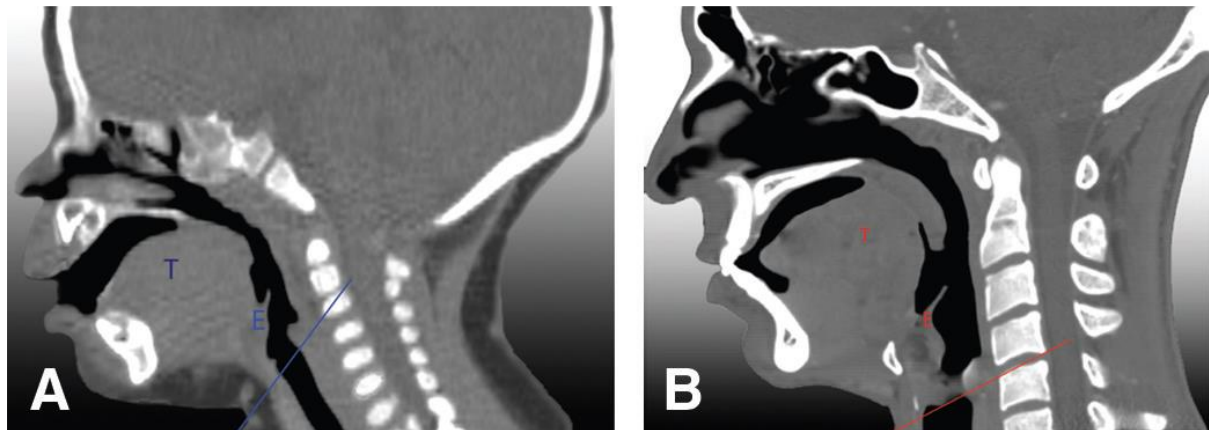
differences between the airways shown on lateral radiography in children and adults. The trachea starts higher at the C2-C3 level in the paediatric airway (A), but in adults, it starts lower at the C4-C5 level (B). Just below the cricoid cartilage is where the trachea starts. Additionally, the tongue (T) occupies a larger portion of the oral cavity in youngsters and the epiglottis (E) is pointed away from the axis of the trachea [17]
